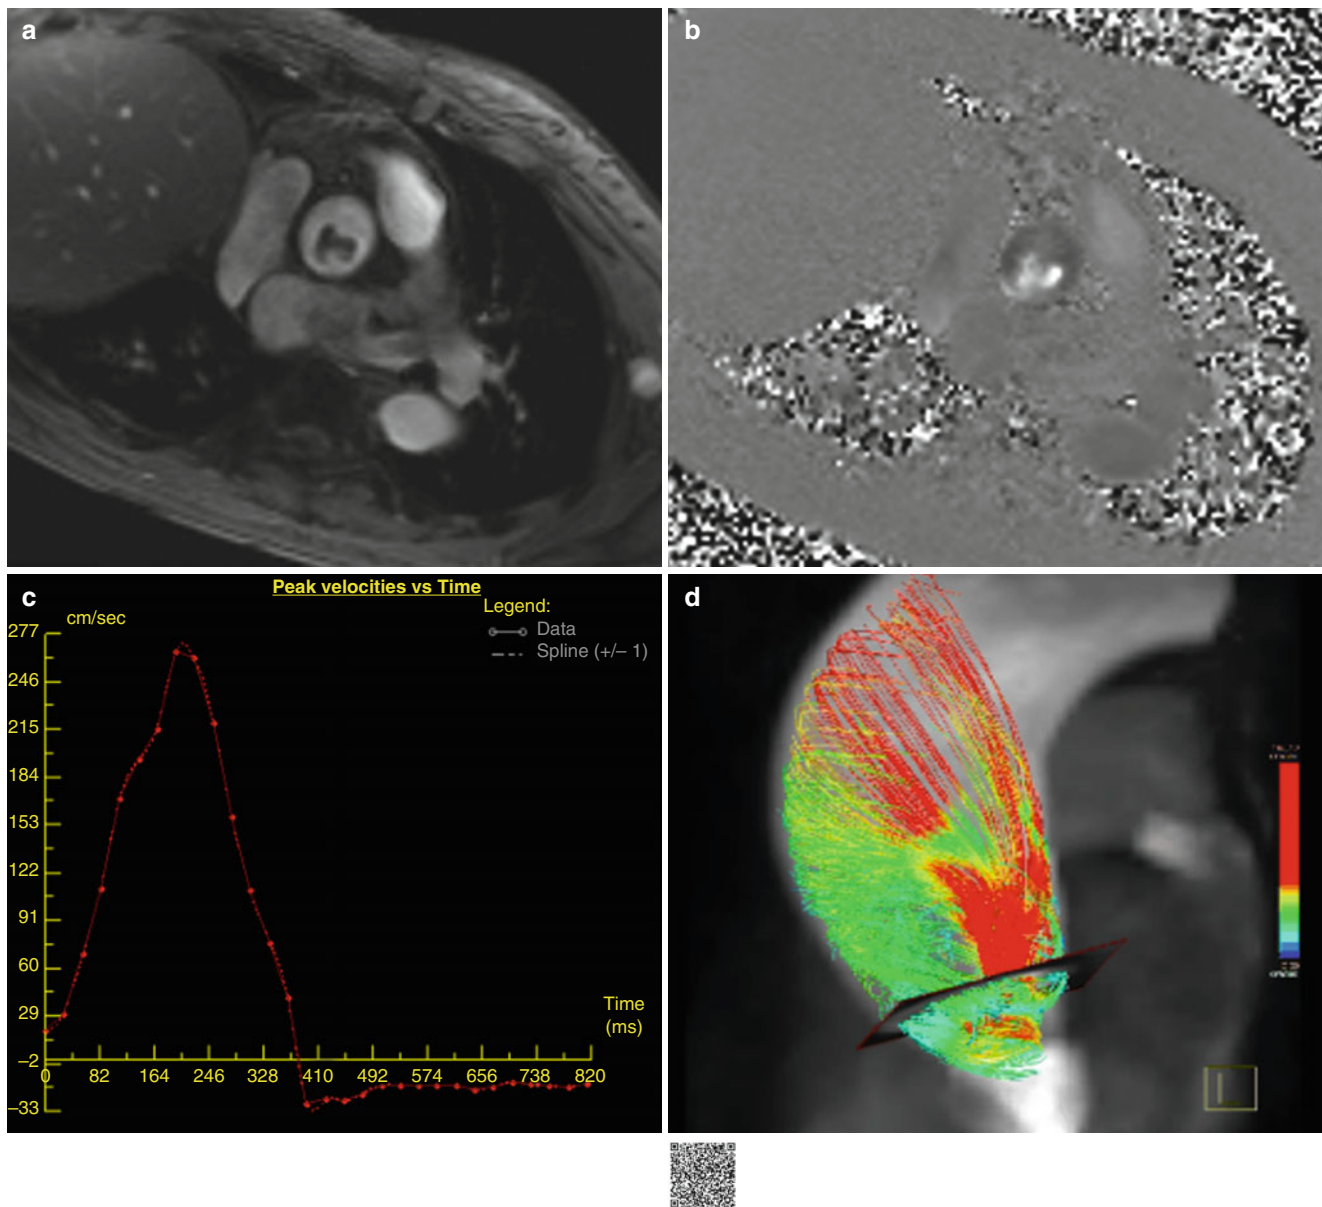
Example of velocity mapping in AS. (a, b) Quantitative through-plane flow assessment above aortic valve using the PC cardiac MRI. Magnitude image (a), phase image (b), corresponding PC velocity map (c), and 4D flow image (d). The peak velocity is 2.7 m/s with an
